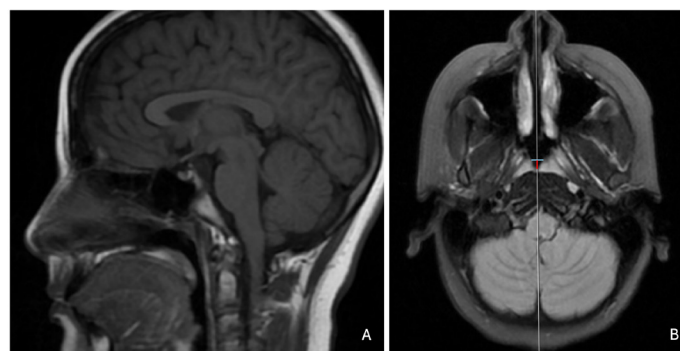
Sagittal and axial T1 FLAIR magnetic resonance images of a 10-year-old female patient. (A) Sagittal view demonstrating absence of Adenoid hypertrophy (AH). (B) Axial view showing the pharyngeal bursa with annotated width (blue line) and height (red line). These images highlight normal nasopharyngeal anatomy and the visualization of the pharyngeal bursa in the absence of adenoid enlargement
